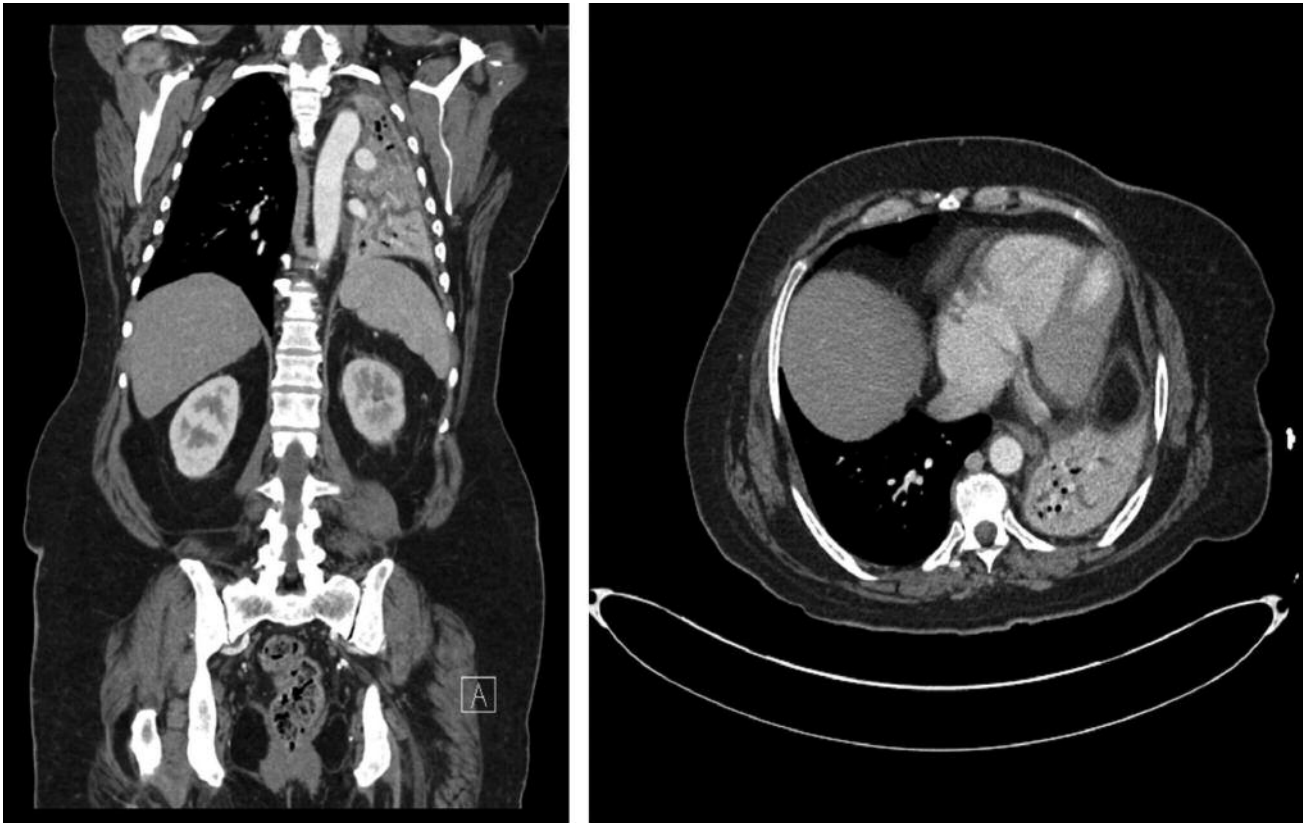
Chest CT scan with complete collapse of the left lung with heterogeneous enhancement of the left lung parenchyma and several foci of entrapped air within dilated peripheral bronchi.
